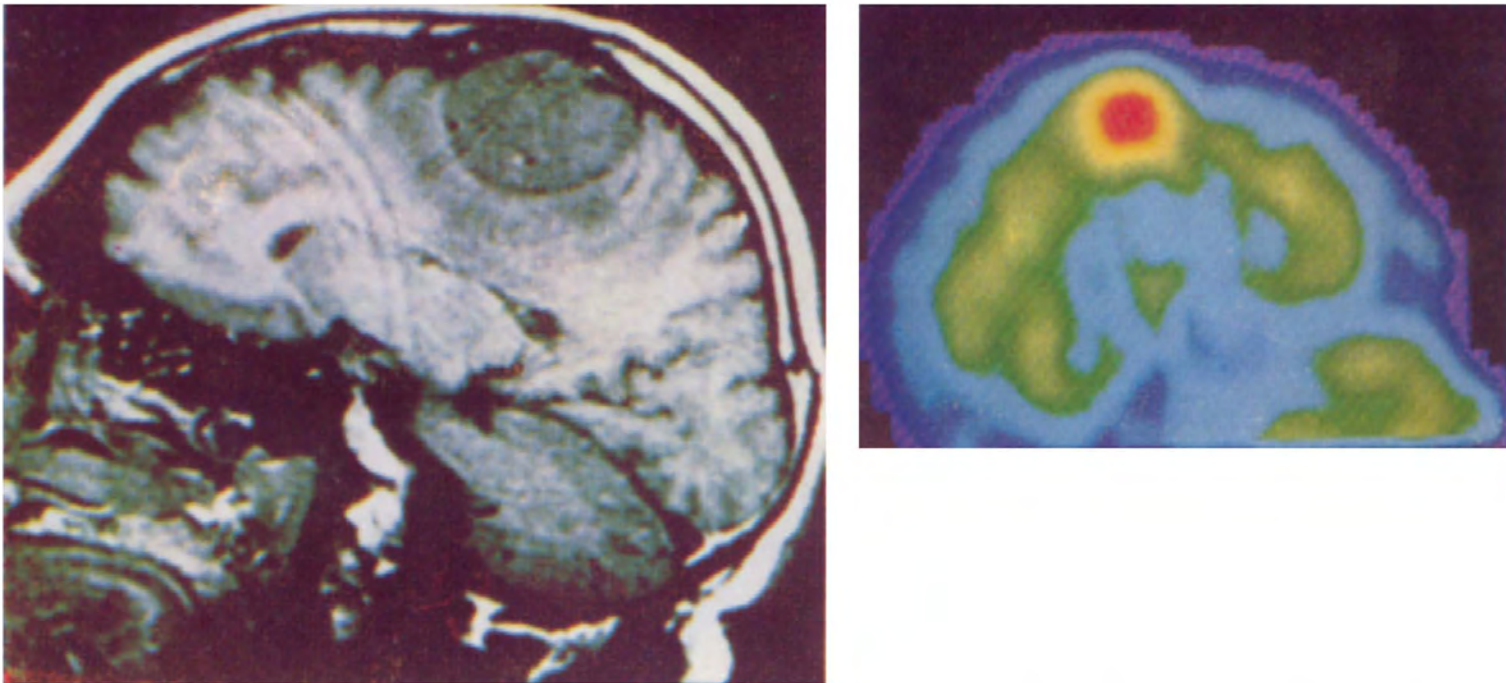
Sagittal MRI (left) and ictal SPECT (right) images in a patient with meningioma showing a hyperperfusion pattern.
